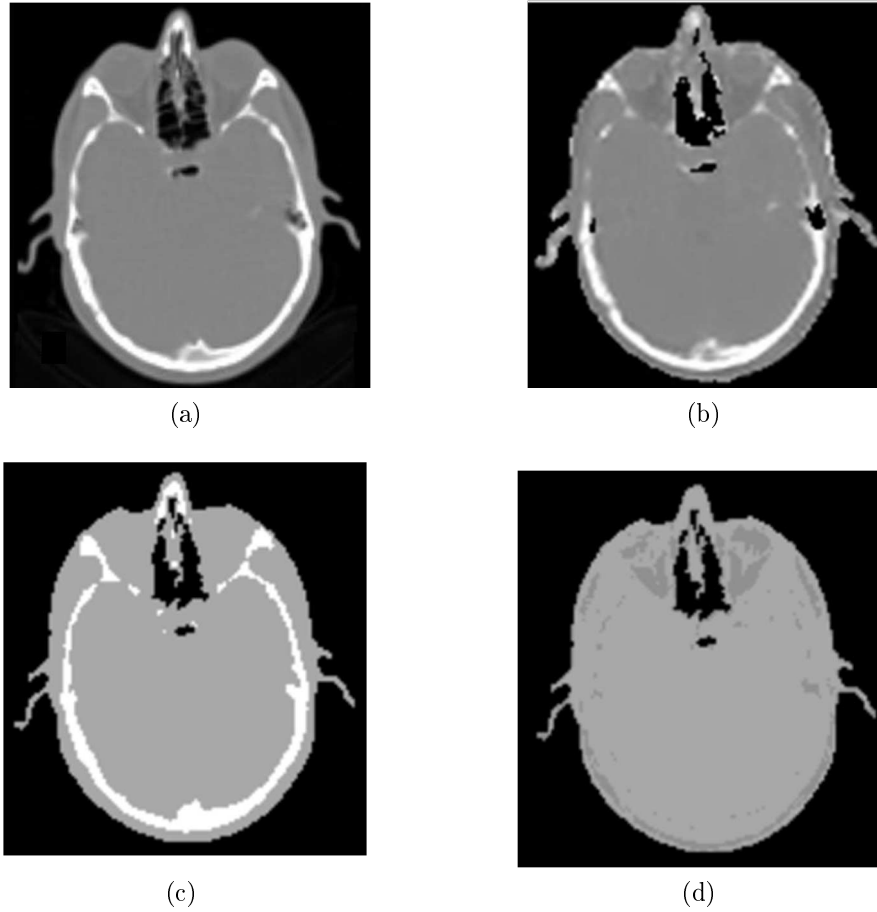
Different attenuation maps used for comparison for PET-AC. Transaxial slices of patient P3 (A) Patient CT:  $\mu\text{-map}_{\text{CT}}$  (B) MR predicted CT:  $\mu\text{-map}_{\text{MR}}$  (C) Four class segmented CT:  $\mu\text{-map}_{\text{bone}}$  (D) Three class Dixon like CT:  $\mu\text{-map}_{\text{nobone}}$
